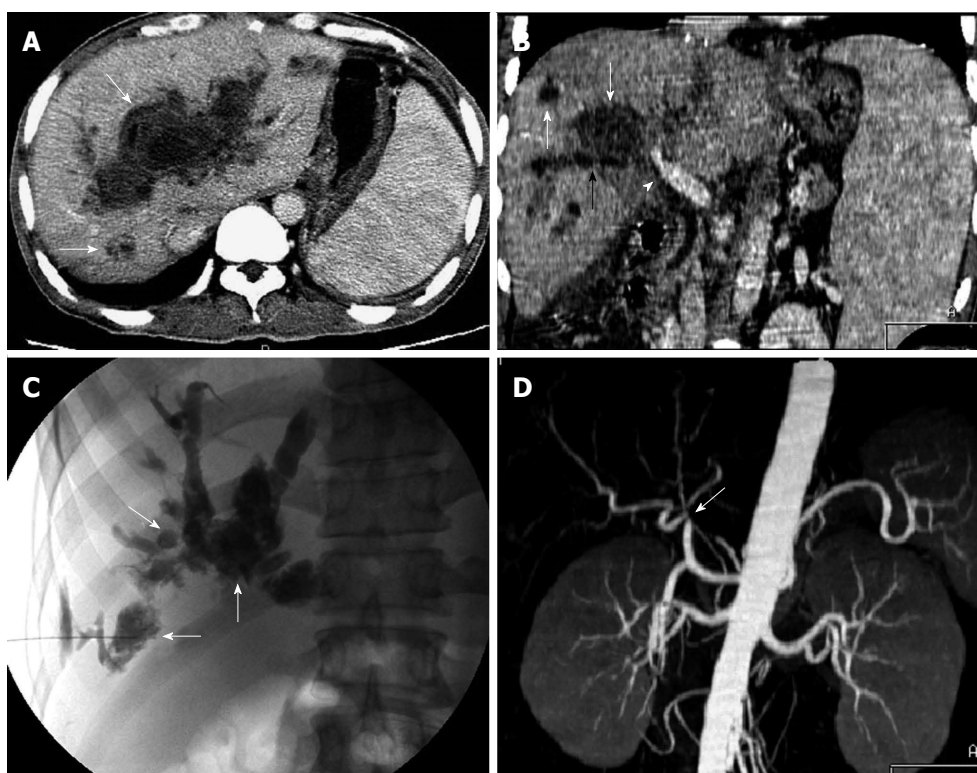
A 46-year-old man with jaundice and fever due to biloma or biligenic hepatic abscess 4 mo after orthotopic liver transplantation. Transverse computed tomography (CT) image in the portal venous phase (A) and oblique reformat image (B) show multiple biloma or biligenic hepatic abscess (white arrow) communicating with the dilated bile ducts (black arrow), and stenosis of the hepatic hilar bile duct (arrowhead); C: Percutaneous transhepatic cholangiography demonstrates biliary dilation, necrosis, and abscess cavity (contrast medium pool) (arrow); D: CT angiography shows hepatic arterial anastomotic stenosis (arrow).
